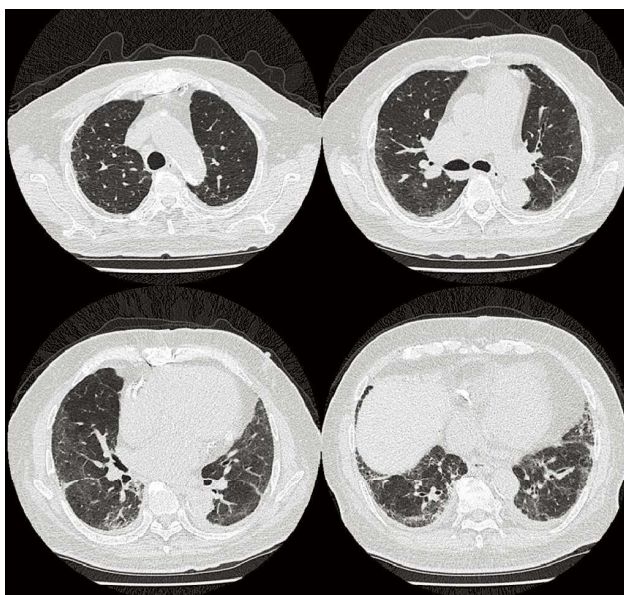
CT 2 months after discharge shows resolving consolidation, with residual fibrotic changes.
